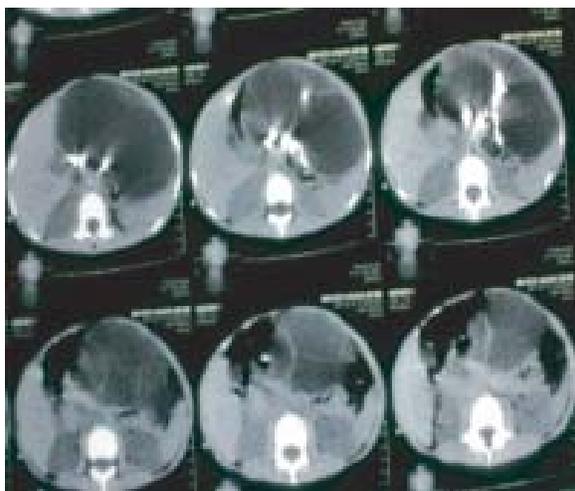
Post contrast axial Computed Tomography showing large multiseptate cystic mass with areas of calcification.
